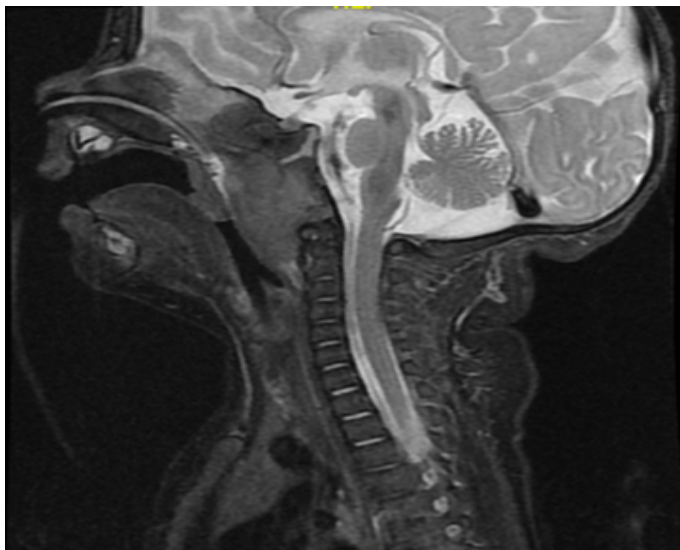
MRI of the nasopharynx and neck.
